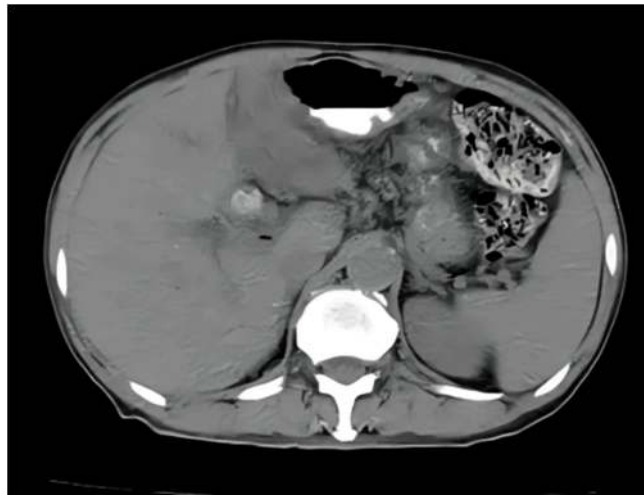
CT Scan of Perihilar Cholangiocarcinoma (Klatskin Tumor) in a 62-year-old Female Patient showing a Mass
